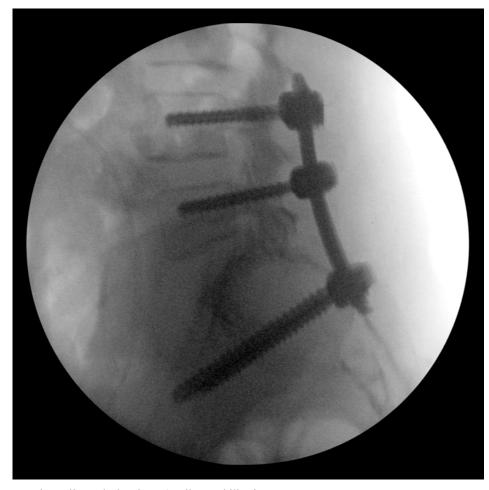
Lateral intraoperative radiograph showing L4 – Ilium stabilization.
